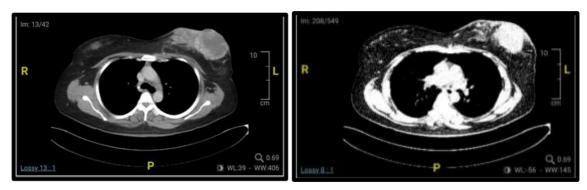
Thoracic MRI with contrast.
